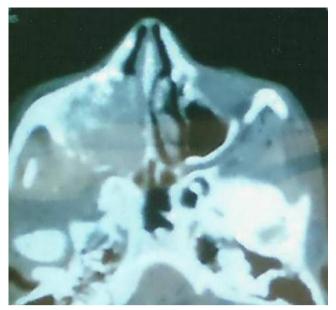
CT Scan of paranasal sinuses showing soft tissue mass: Axial view
